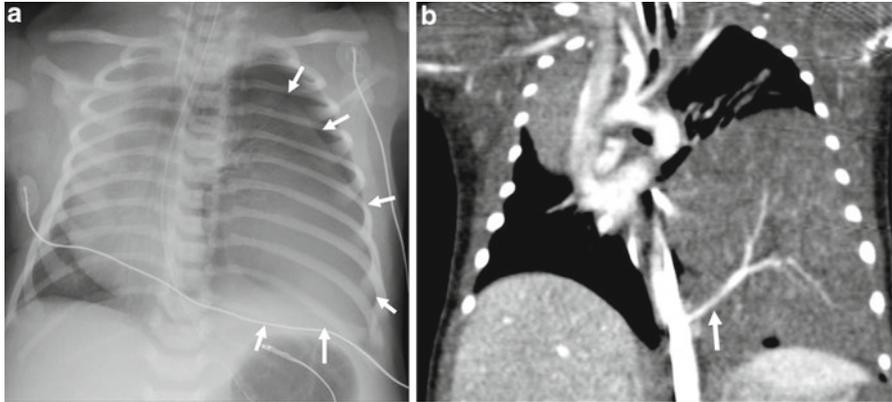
Pulmonary sequestration. (a) Chest radiograph shows a well-defined left lung opacity (*arrows*) and significant mediastinal shift to the right. (b) Coronal CT image shows a large left lower lobe solid mass and a feeding vessel (*arrow*) arising from the aorta
